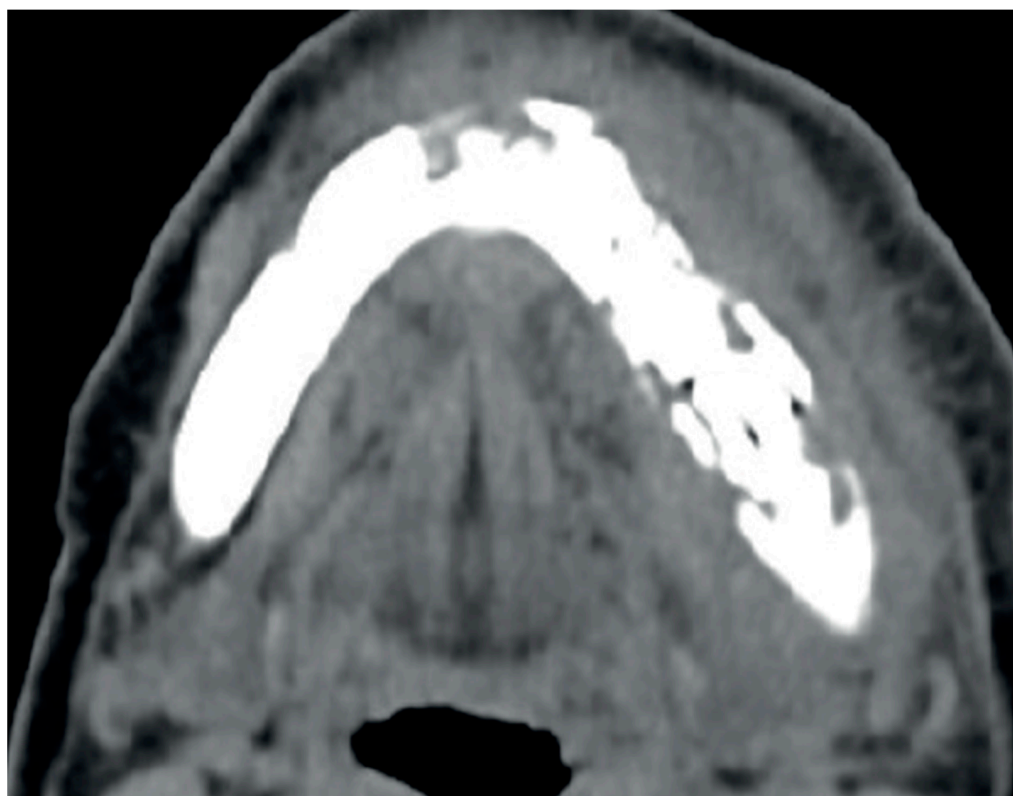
Computed tomography with contrast. Multifocal necrotic changes of the mandibular body in the mental sections and the left molar area.
